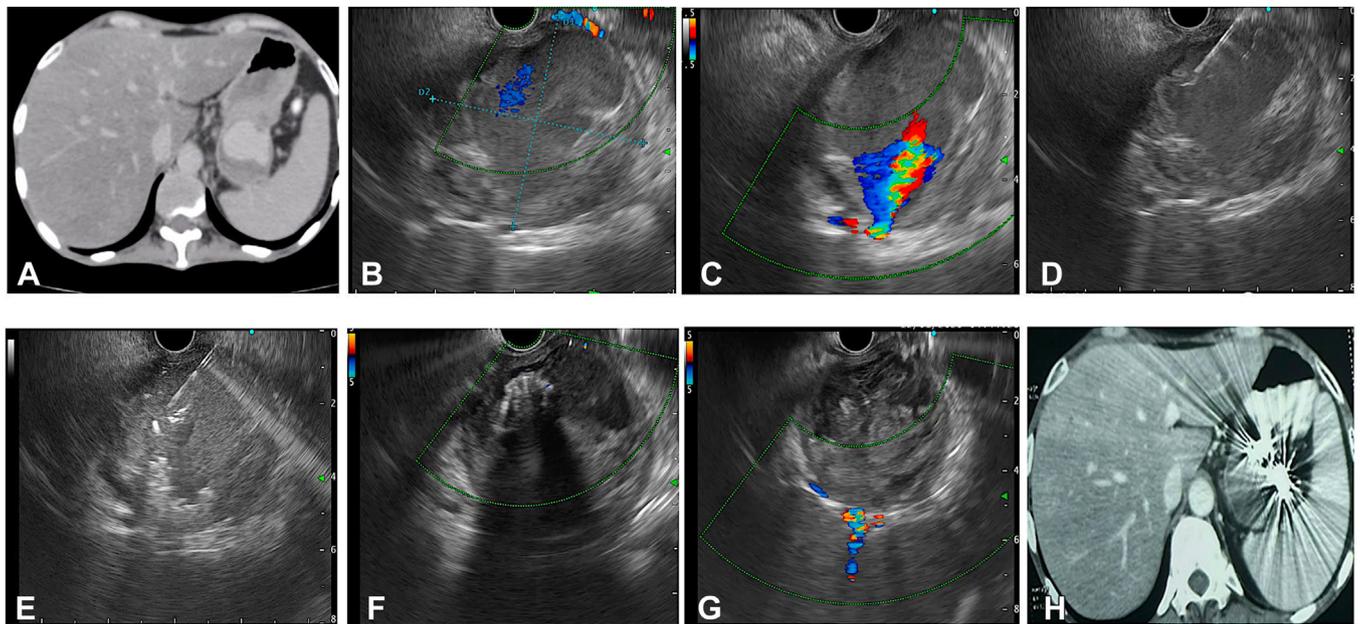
EUS-guided embolization of a large splenic artery pseudoaneurysm. A, Contrast-enhanced CT scan of the abdomen showing large vascular lesion at the tail, enhanced on venous phase. B, A large lesion was identified as a pseudoaneurysm on EUS. C, Doppler flow confirmed active ooze from the splenic artery into the pseudoaneurysm. D, The pseudoaneurysm was punctured with a 19-gauge needle on EUS. E, Coils were deployed under EUS guidance. F, After injection of coil and glue, EUS showed disappearance of Doppler flow within the pseudoaneurysm, with coil–glue complex seen within. G, Doppler flow confirmed cessation of the ooze from the splenic artery. H, Contrast-enhanced CT scan of the abdomen showed no flow within the lesion, with artifacts seen from the coils.
